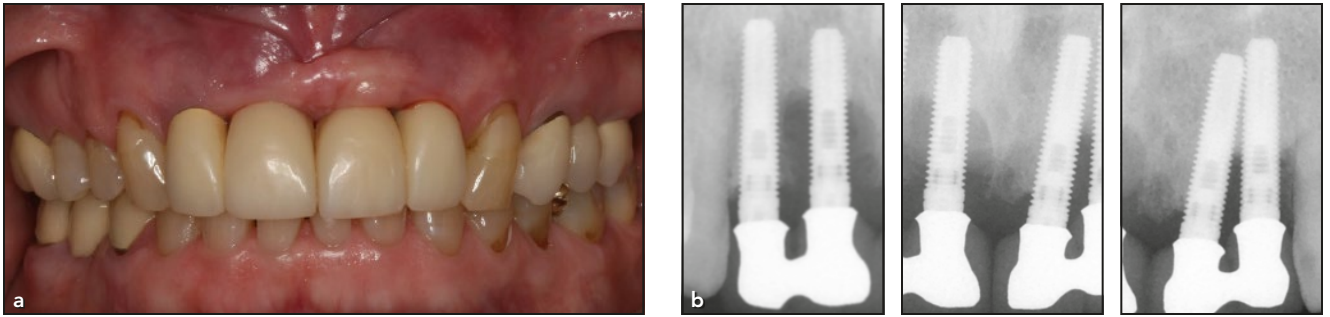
Case at presentation. (a) Frontal view. (b) Periapical radiographs of maxillary incisor implants.
